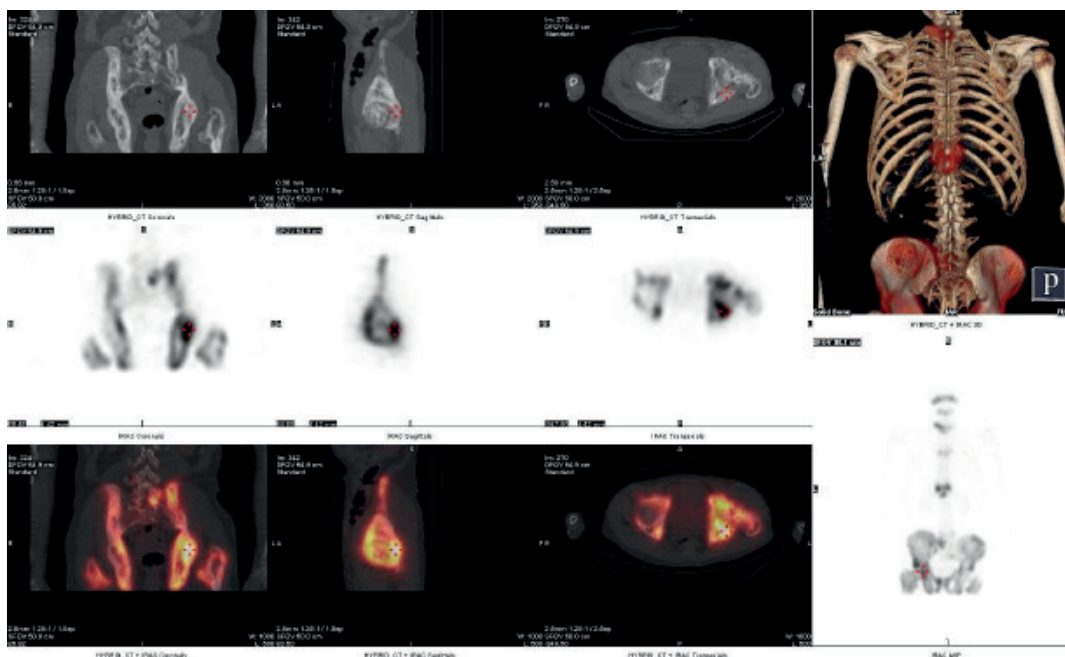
SPECT/CT of os coxae.
